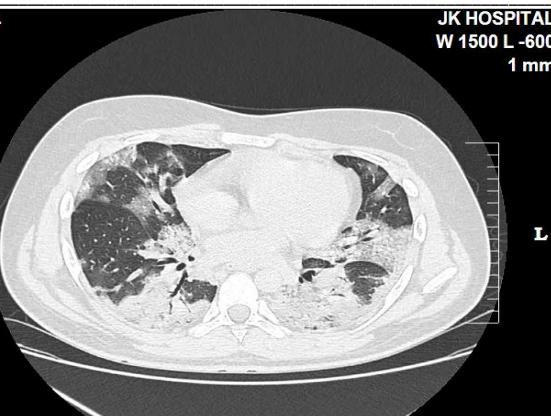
HRCT of young patient age between 20-25 year showing multiple confluent patches of GGO with consolidation CT severity score; 17-19 (Moderate lung involvement).
